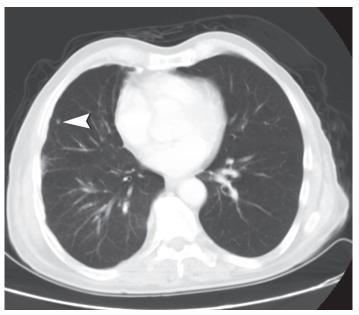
Axial non- contrast enhanced CT a milimetric parenchymal nodul in right middle lobe (arrow head).
